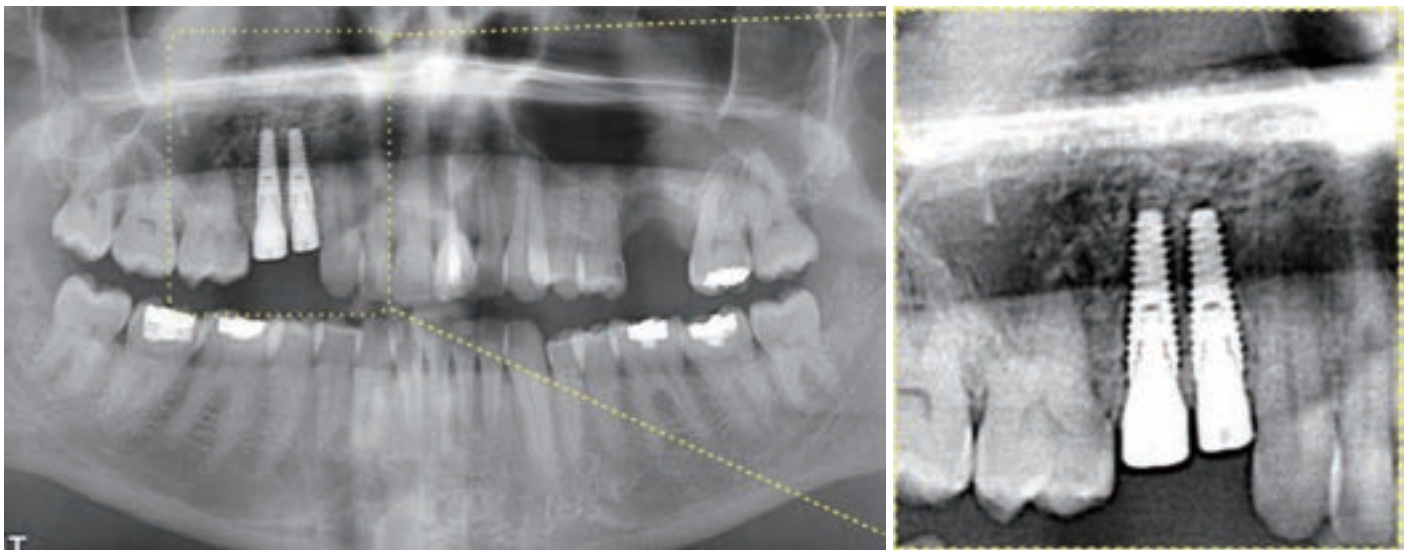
Panoramic and CT scan should be taken after the surgery to verify proper grafting of maxillary sinus without perforation. It is more important to note the horizontal compaction of the bone graft touching the medial and lateral walls, which maximize the blood supply to the graft and determines the longevity of the graft after loading.
